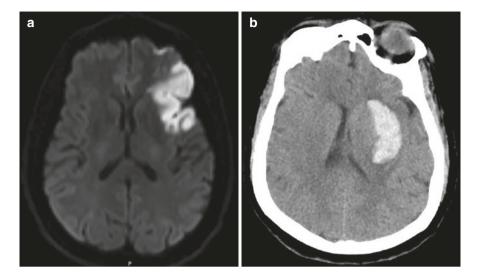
(a) Brain MRI with acute left frontal ischemic stroke. (b) Brain CT with acute left basal ganglia intracerebral hemorrhage
